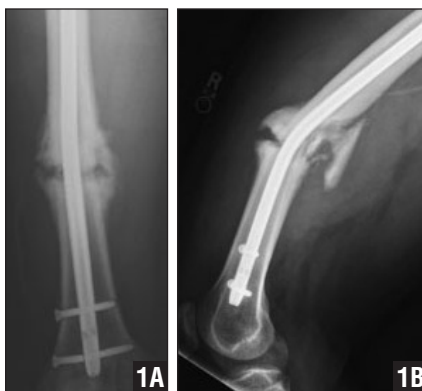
Preoperative anteroposterior (A) and lateral (B) radiographs revealing an apex-anterior deformity around a bent femoral intramedullary nail.
